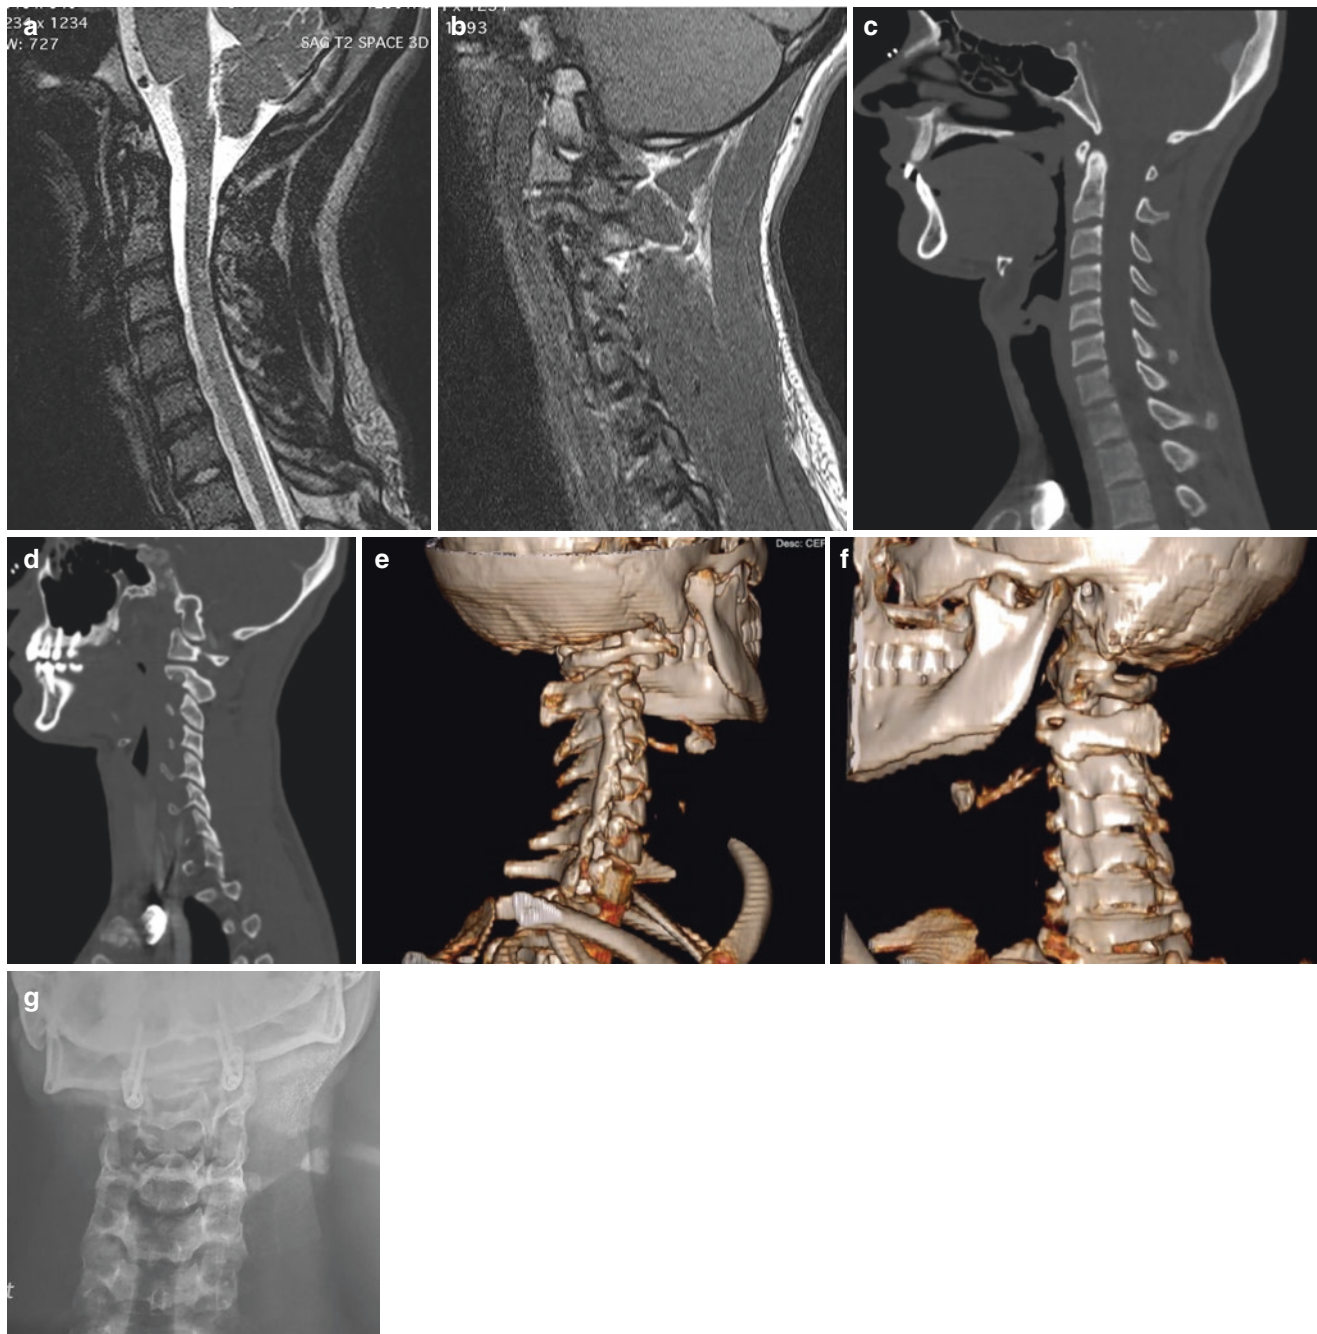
Images of an 18-year-old male patient. (a) T2-weighted MRI showing no evidence of compression at the craniovertebral junction. (b) Sagittal cut of MRI through the facets showing type 3 facet instability. (c) Sagittal CT scan showing a normal atlantodental interval. (d) Sagittal cut of CT scan passing through the facets showing the type 3
